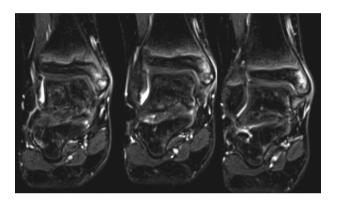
Consecutive coronal fat suppressed T2W MR images.
